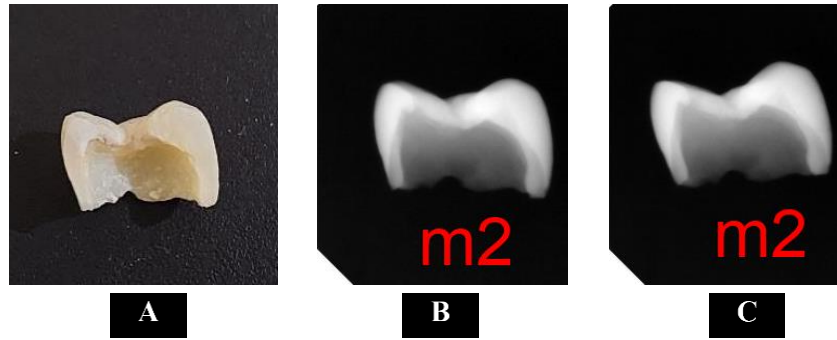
Sample with 30 Gy irradiation (A) Clinical photograph, radiograph image of pre-irradiated Tooth Enamel of Molar and (C) post-irradiated
